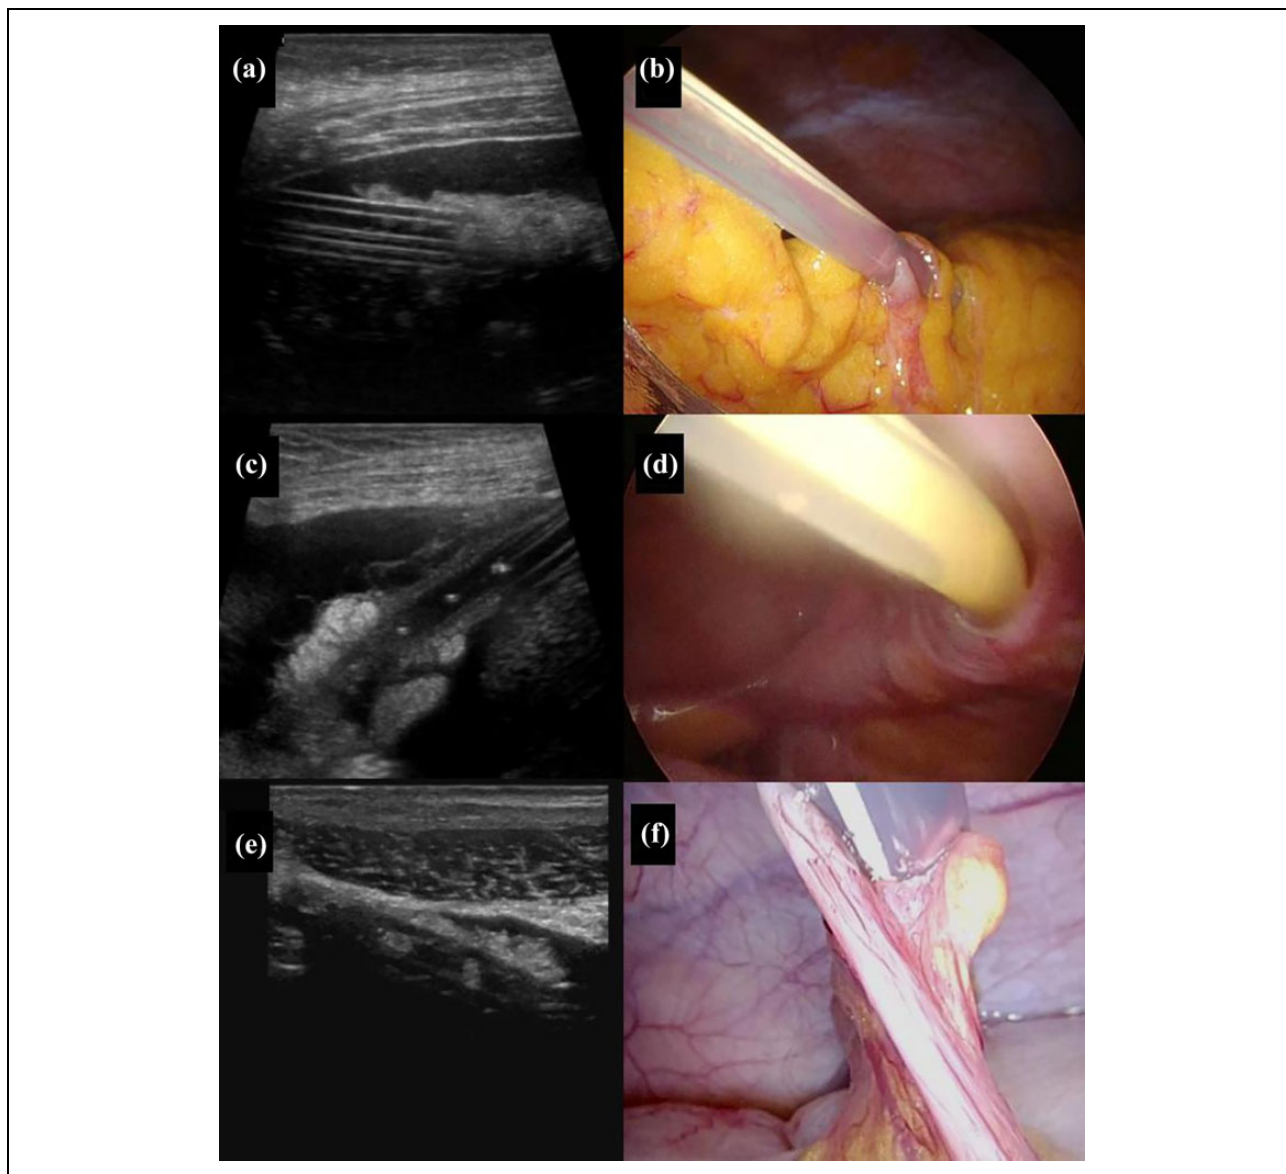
Ultrasound examination of peritoneal catheter malfunction (left side) and the corresponding view at videolaparoscopy intervention (right side). (a) and (b): Ultrasound examination with a 9-MHz linear probe, maximum scanning depth of 5 cm, showing hyper-echoic material attached around the distal part of the peritoneal catheter. Videolaparoscopy confirmed the ultrasound diagnosis of omental wrapping and entrapment of omentum in some of the catheter side holes. (c) and (d): Ultrasound examination with a 9-MHz linear probe, maximum scanning depth of 5 cm, showing hyper-echoic tissue attached around the distal part of the catheter and presence of a thin layer around the proximal part of catheter. Videolaparoscopy confirmed omental wrapping and fibrin sheath formation. (e) and (f): Ultrasound examination with a 12-MHz linear probe, maximum scanning depth of 4 cm, showing hyper-echoic tissue around the catheter and oval hyper-echoic structures in the catheter lumen (matching with some of the catheter side holes) despite preceding catheter brushing. Videolaparoscopy evidenced omental wrapping and entrapment of omental tissue inside the catheter lumen across the side-holes.
